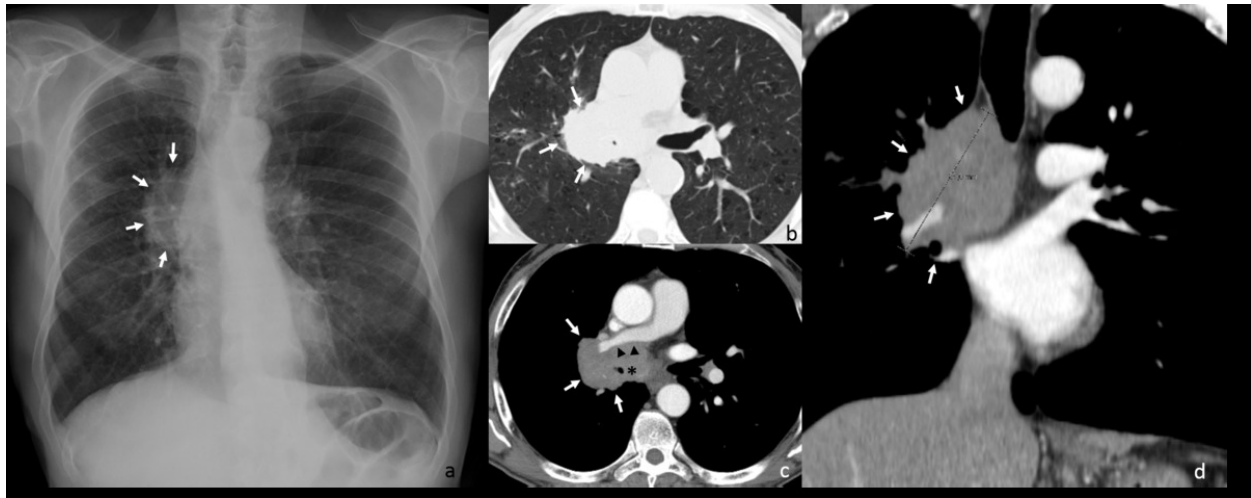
Abnormality of the right hilar contour with a convex hilar angle (white arrows in a). The absence of hilar overlay sign demonstrates the hilar origin of this mass. Left tracheal deviation is also seen. The CT demonstrated the presence of a mass (white arrows in b, c and d) involving the right main bronchus (asterisk in c) and the right interlobar pulmonary artery (black head arrows in c). The mass proved to be a bronchogenic carcinoma.
